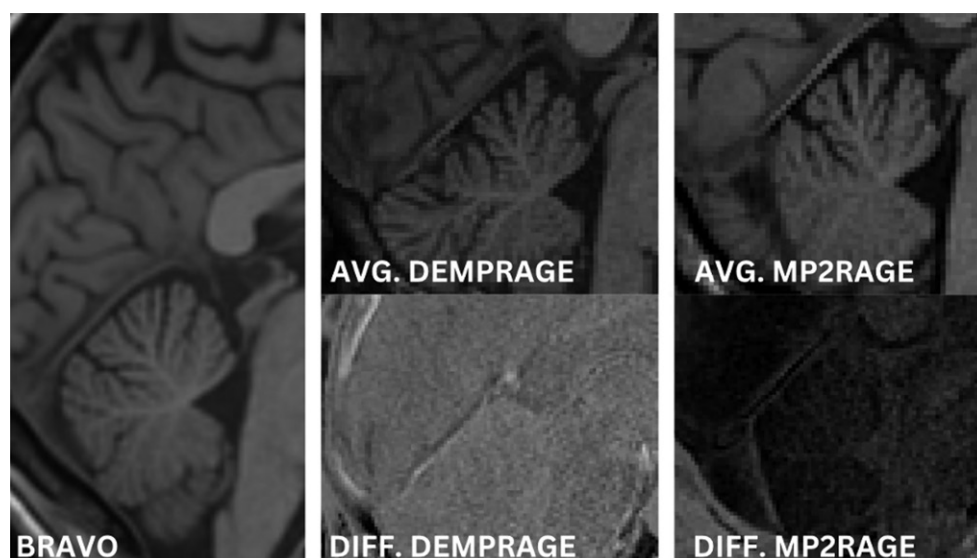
MR images depict various modalities. The far-left image depicts the BRAVO modality, the top middle row depicts the average DEMPRAGE image combining both TEs, followed to the right by the average MP2RAGE image combining both TIs. The bottom middle row depicts the difference DEMPRAGE image, and the far-right image shows the MP2RAGE difference image. Note that the difference images clearly highlight the tentorium structure.
